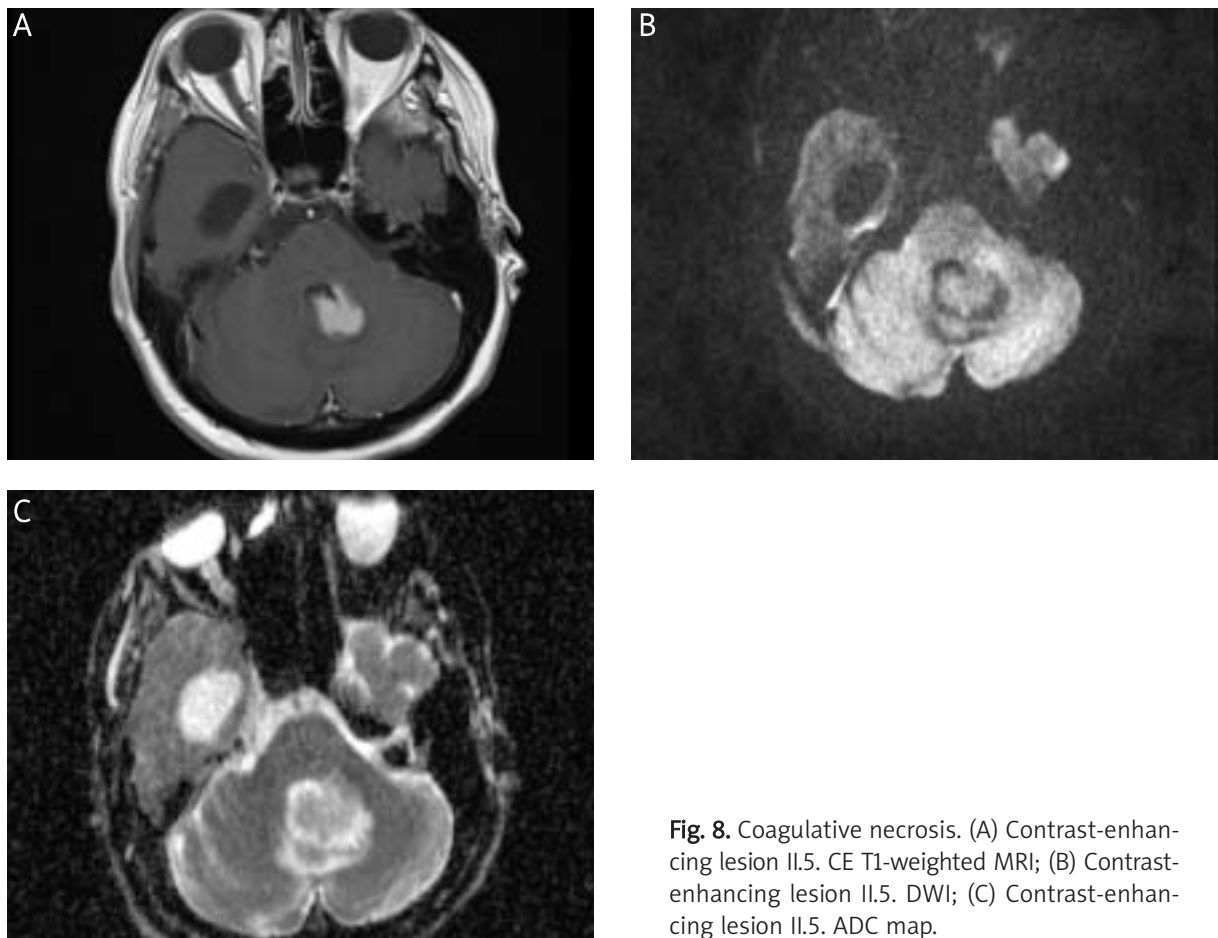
Coagulative necrosis. (A) Contrast-enhancing lesion II.5. CE T1-weighted MRI; (B) Contrast-enhancing lesion II.5. DWI; (C) Contrast-enhancing lesion II.5. ADC map.
